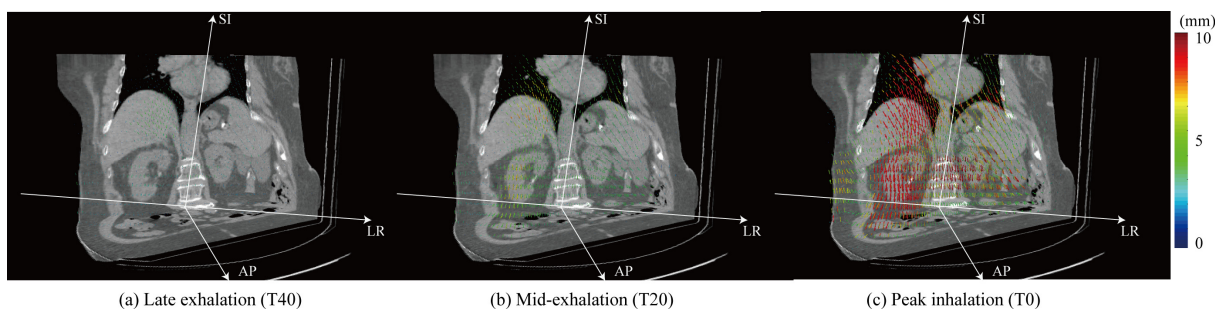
Intrafractional motion map (shown as arrows) overlaid on the CT images (oblique view). (a) Late exhalation (T40), (b) mid-exhalation (T20) and (c) peak inhalation. Arrow starting and end points were peak exhalation (T50) and each phase, respectively. Large displacements were observed around the right liver region.
